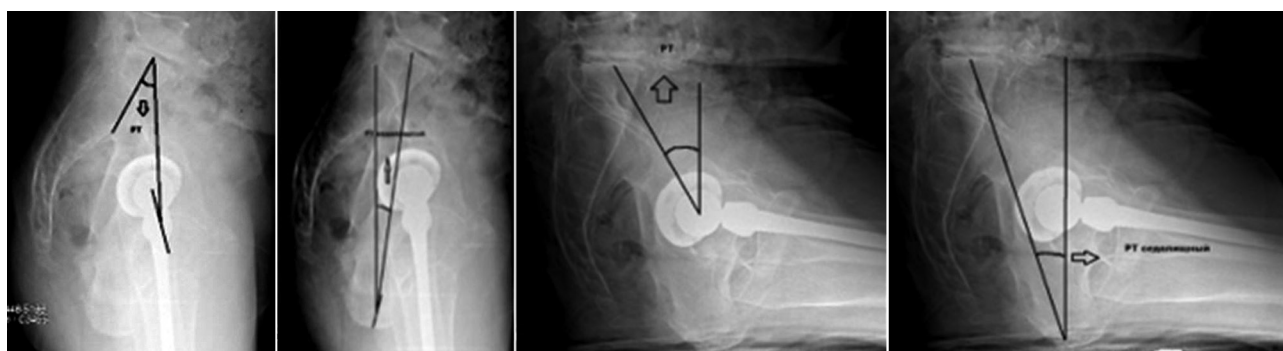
Lateral radiograph of the pelvis in standing position: *a* finding the PI angle in standing position; *b* finding the PI ischial angle in standing position
